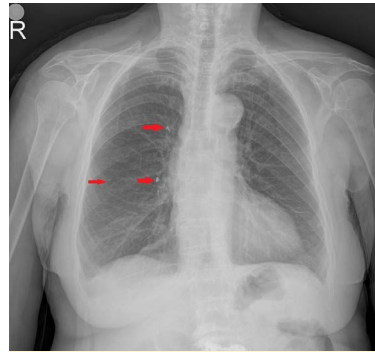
Chest X-ray, pulmonary cement pieces and vertebroplasty materials in L3 vertebral body.
